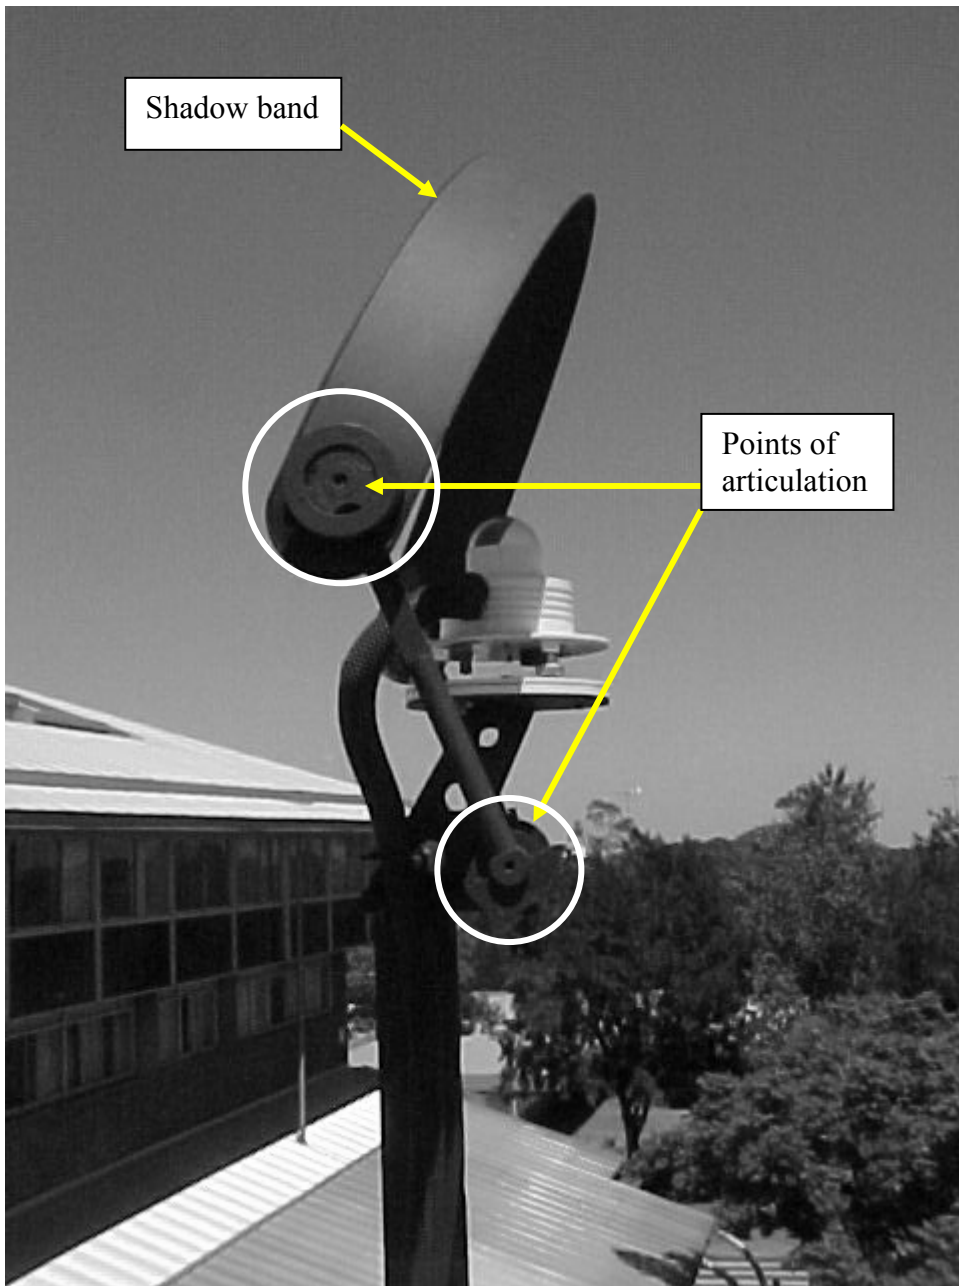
Shadow band and SUV meter that comprise the diffuse SUV meter.
